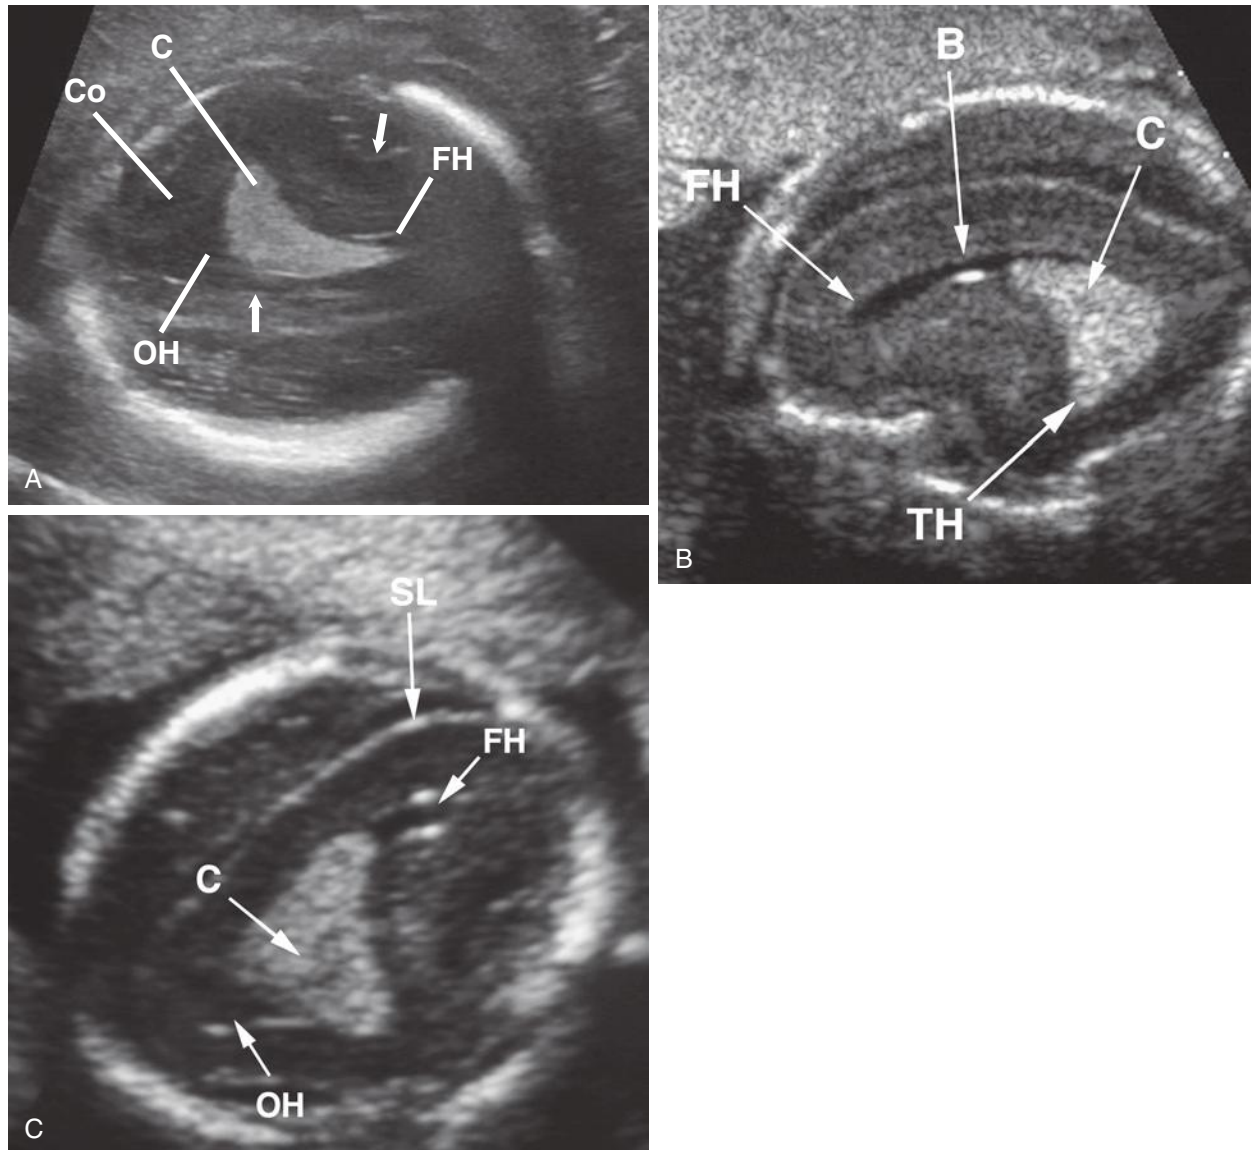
A through C, Parasagittal sonograms through the ventricle of 16- to 18-week fetuses. The choroid (C) defines the ventricular size and the position of the ventricular atrium. Note the substantial increase in cortical brain (Co) thickness compared with fetuses only a few weeks younger (see Fig. 8-104). Bright echoes marginate the edge of the telencephalon (*straight arrows*). The bright reflector represents surface leptomeninges (SL). Note the beginnings of an occipital horn (OH) in A, and compare with the more developed occipital horn in C. Note, as well, that the frontal horn (FH) is much narrower in craniocaudal diameter because growth of the head of the caudate nucleus has reshaped this portion of the ventricle. B, ventricular body; TH, developing temporal horn.
